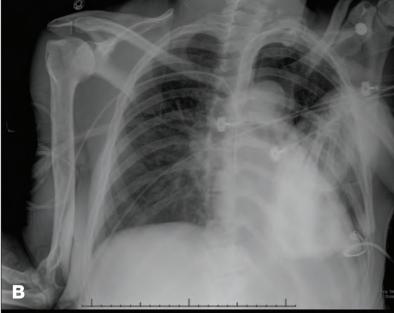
Representative X-rays showing upper extremity contractures
